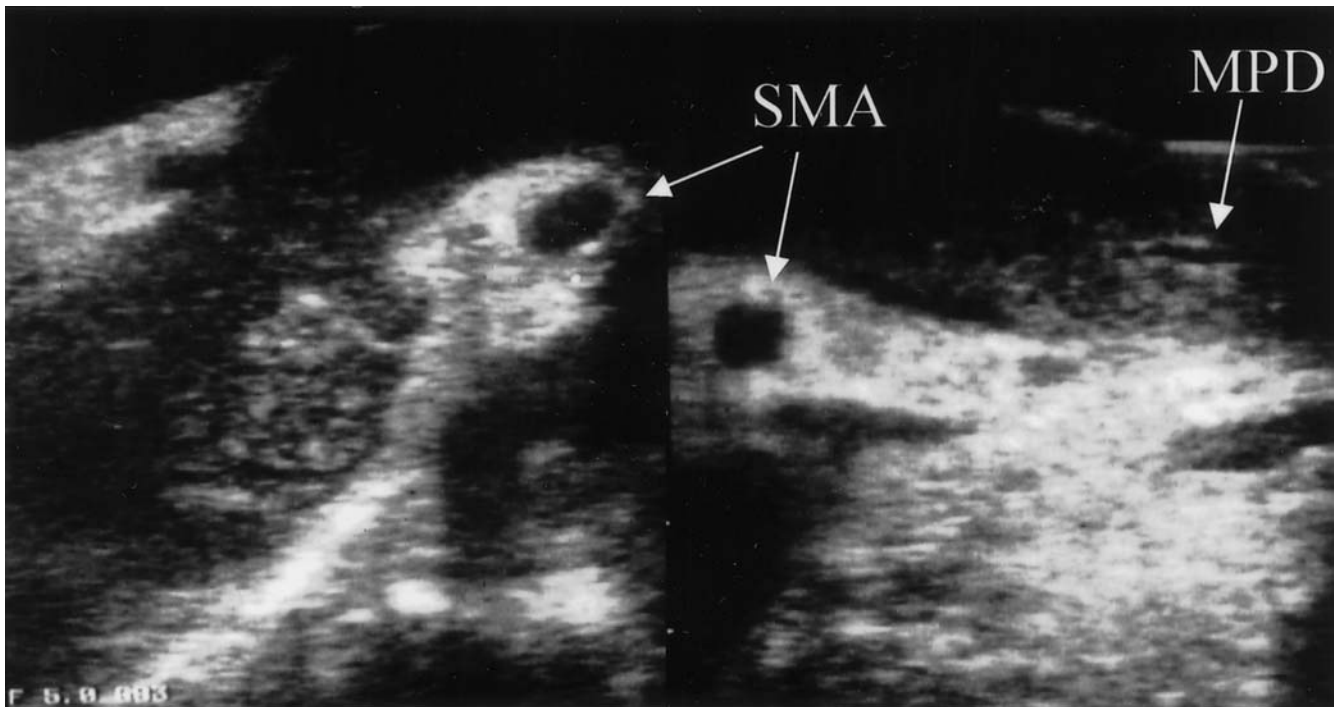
Operative ultrasound examination, revealing enlarged entire pancreas without any circumscribed tumor in the pancreas. *SMA*, superior mesenteric artery
